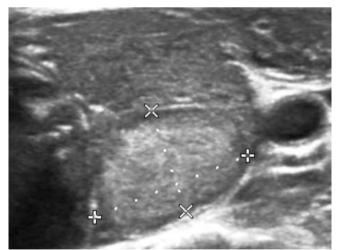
Ultrasound image showing a well-defined hyperechoic thyroid nodule. The rest of the background thyroid parenchyma is heterogeneous in appearance- Nodular thyroiditis pattern.
